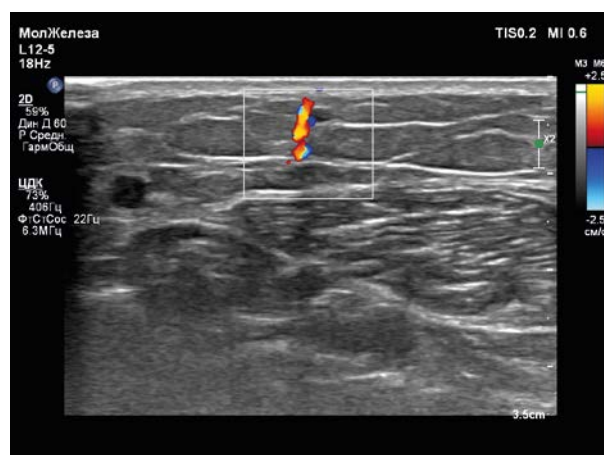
Perforant artery in color Doppler mapping mode.
